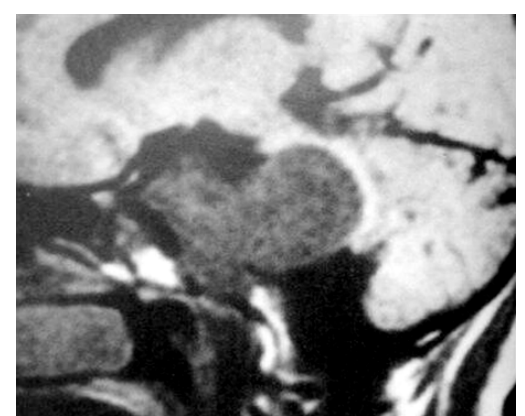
MRI showing a large clival chordoma. Extended middle fossa approach was used to radically resect this tumour
